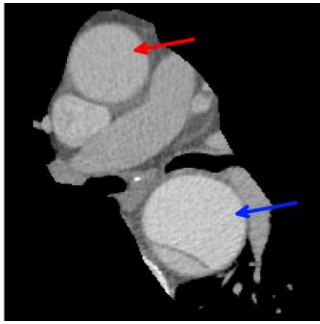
A single image from the CT dataset after a rough cropping and windowing. The ascending aorta is indicated with a red arrow and the descending aorta is indicated with a blue arrow.
